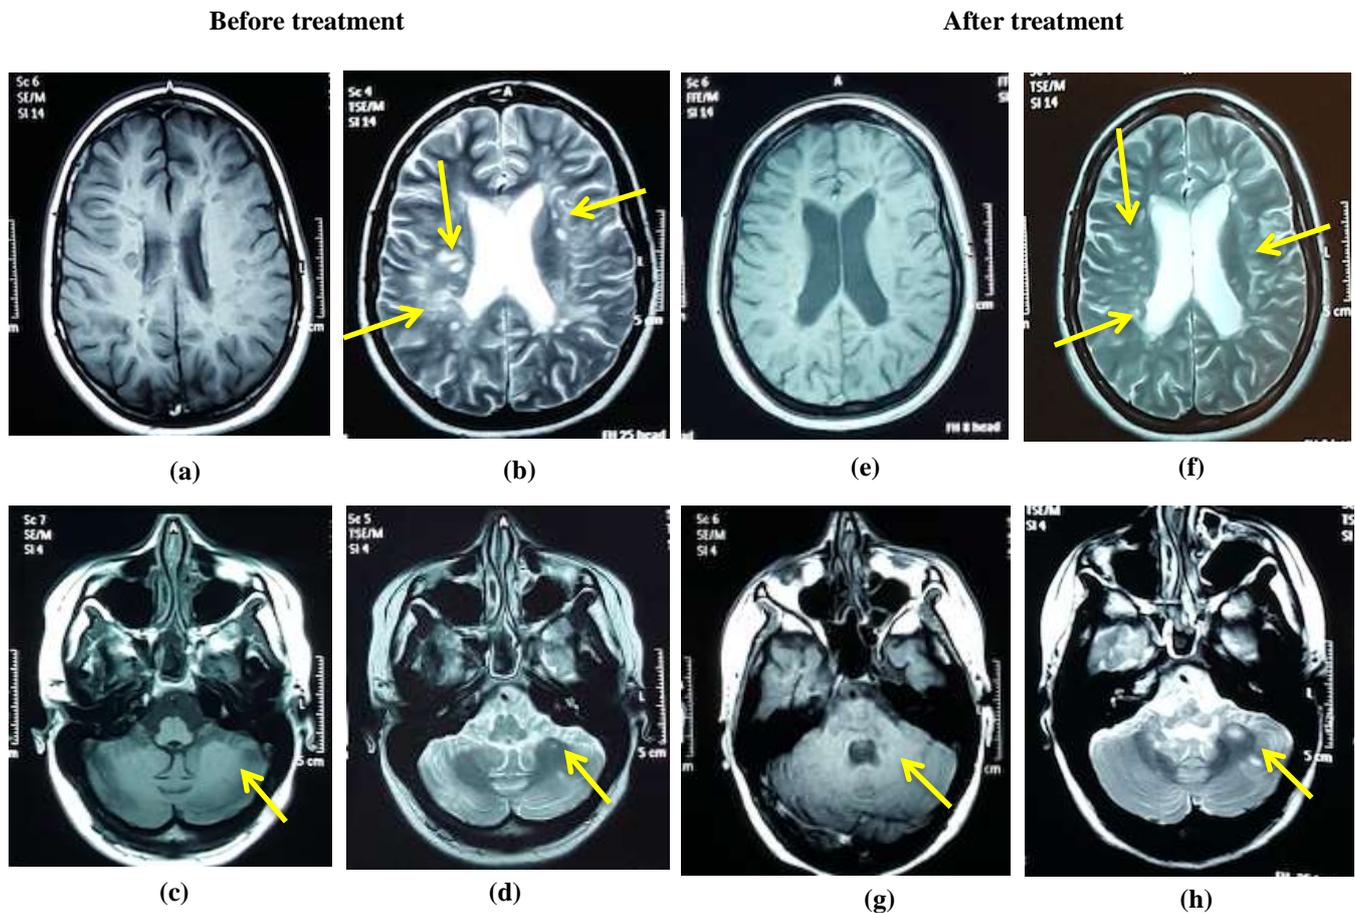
Non-contrast head MRI before treatment: (a) T1WI axial and (b) T2 WI axial slices show multiple bilateral periventricular and subcortical lesions, (c) T1 WI axial and (d) T2 WI axial slices show multiple lesion in left cerebellum hemisphere. Non-contrast head MRI after treatment: (e) T1 WI axial and (f) T2 WI axial slices show multiple bilateral periventricular and subcortical lesions, (g) T1 WI axial and (h) T2 WI axial show multiple lesion in left cerebellum hemisphere
